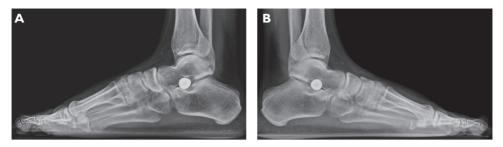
Lateral X-ray of the right foot (A) and left foot (B), showing arthrodesis with a screw between the talar and calcaneal bones.
